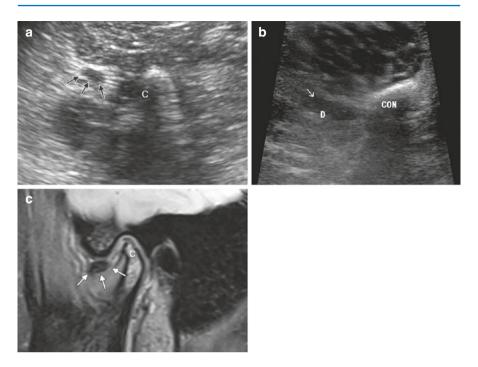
Late-stage internal derangement with anterior disc displacement without reduction and disc deformation. (a) Wide-field of view 8 MHz low-resolution neonatal head probe inserted intraorally for sagittal sonography shows an anteriorly displaced, deformed disc (arrows) with low (dark) echogenicity. (b) Higher-resolution hockey-stick probe sonogram also shows disc (D) displacement (arrow) and deformation. (c) Sagittal MR shows anterior disc displacement (arrows) and disc deformation. *C* condyle, *CON* condyle
